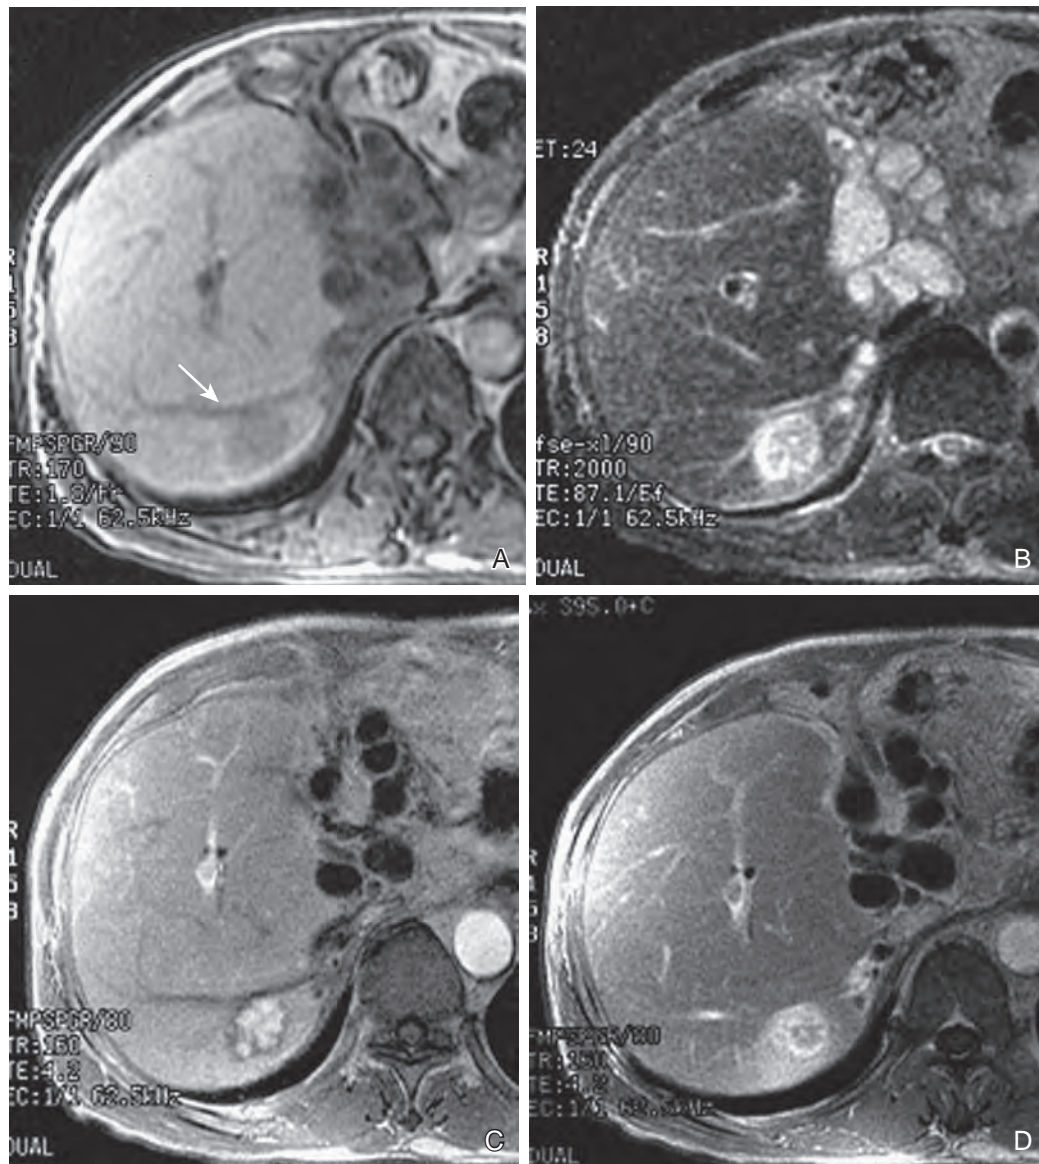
Inflammatory pseudotumor. A. T1-weighted MR image shows a hypointense lesion in the posterior aspect of the right hepatic lobe (arrow). B. The lesion is hyperintense on T2-weighted images. Note the dilated biliary ducts due to cholangitis. C. Gadolinium-enhanced arterial phase T1-weighted MR image shows enhancing inflammatory pseudotumor. D. On the delayed phase images, the enhancement of the liver parenchyma surrounding the tumor indicates inflammation. (Courtesy Dr. Tomoaki Ichikawa, Yamanashi University, Yamanashi, Japan.)
